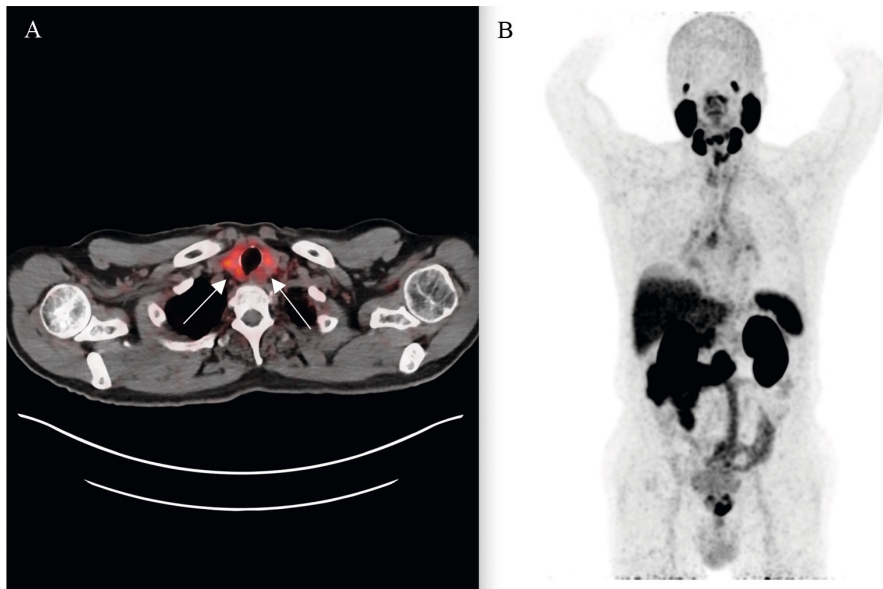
Diffuse thyroidal PSMA uptake on both sides on A) ^{68}Ga -PSMA PET/CT fused image and B) ^{68}Ga -PSMA PET/CT maximum intensity projection (MIP) image.
